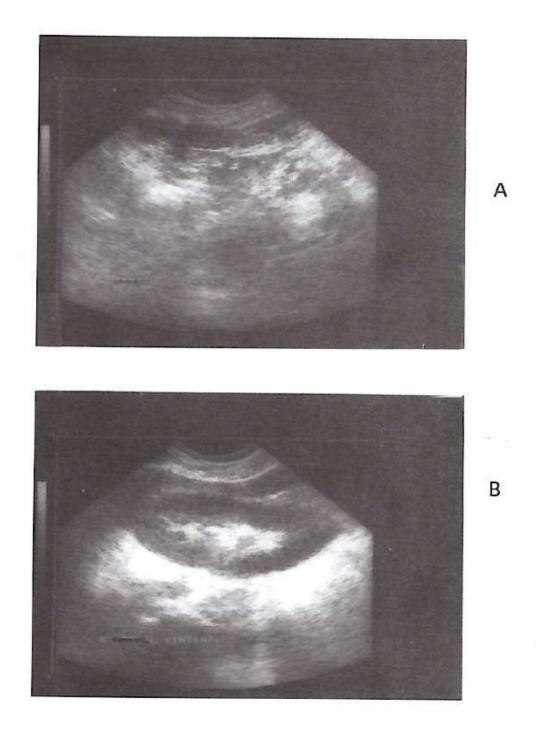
M. Vincenzo, aged 29; Ultrasound scanning:
